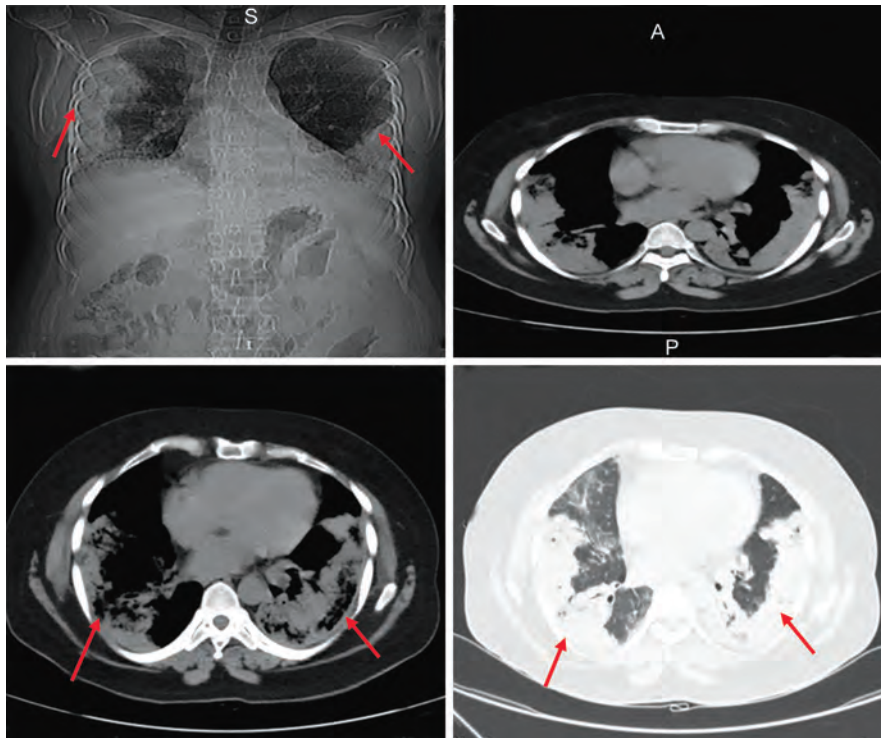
HRCT chest sagittal and coronal view depicting peripheral patchy consolidation
